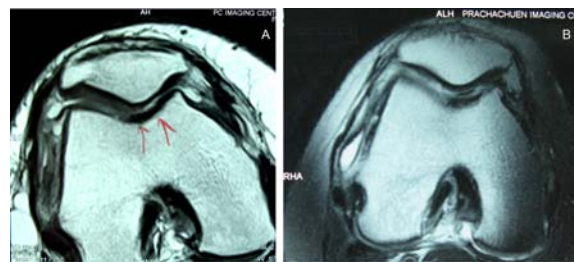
The MRI at 3 months after ACI (A) showed good regenerative tissue formation within the defect, and 1 year (B) showed mild lamination
